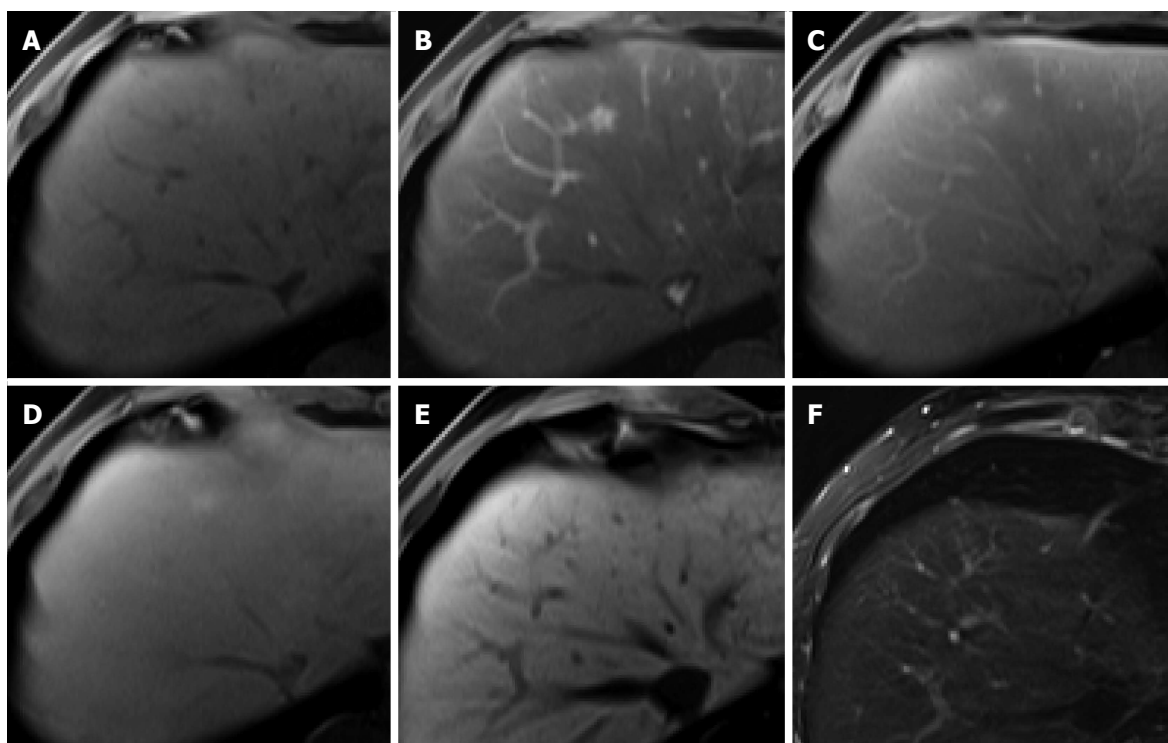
Focal nodular hyperplasia-like nodule in a 45-year-old man with hepatitis B infection. A: Precontrast T1-weighted image shows isointensity of the tumor; B: Hepatic arterial phase using gadoxetic acid shows lobulating-contoured, marked enhanced nodule in segment 4; C, D: Portal venous and transitional phases show slight hyperenhancement of the tumor relative to the liver parenchyma; E: Hepatobiliary phase shows isointensity or subtle peripheral ring-like enhancement of the tumor; F: T2-weighted image shows isointensity of the tumor.
